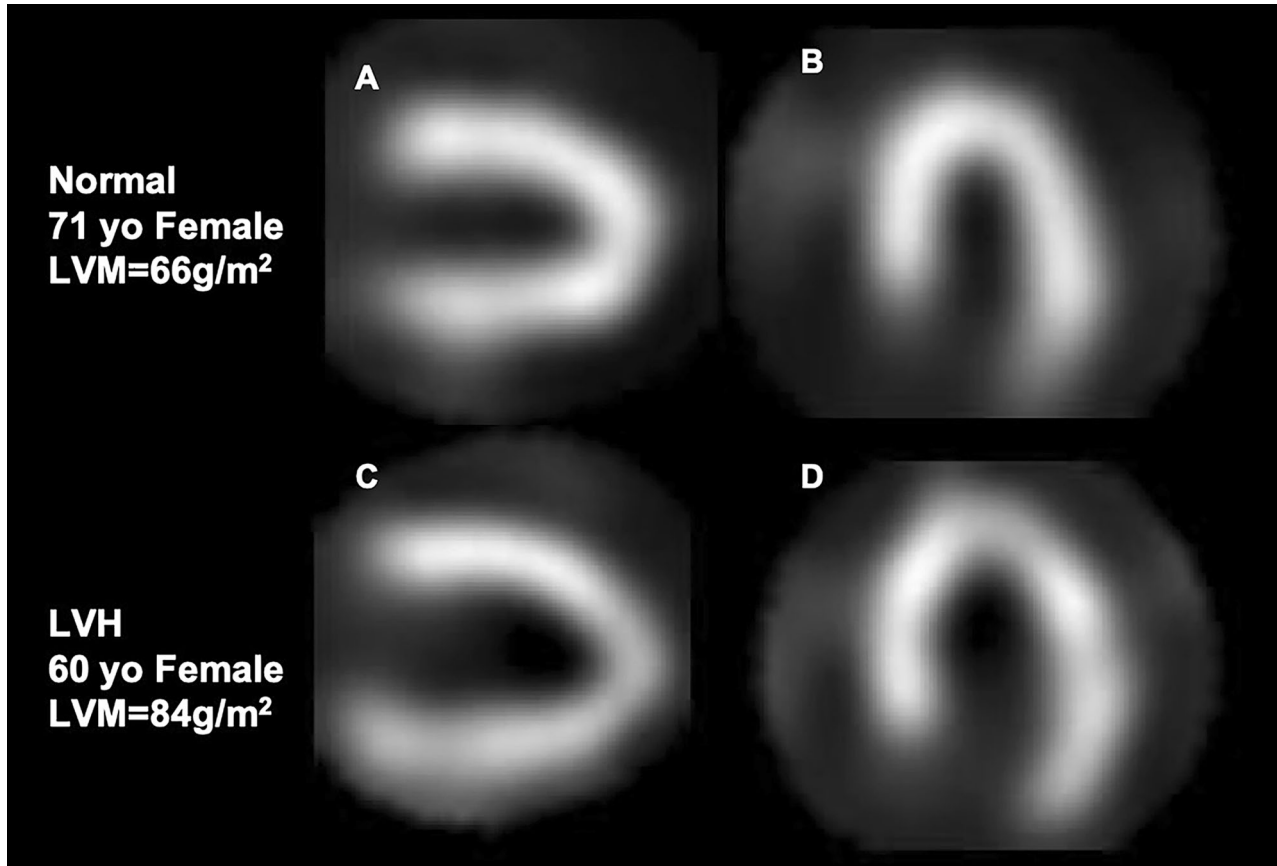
Left ventricular mass estimates. SPECT images were acquired (Discovery NM530c, GE Healthcare) 30 minutes after rest injection with Tc-99m tetrofosmin (~ 150 MBq, 4 mCi). Display zoom 1.3 for all images. A and B Normal patient. LVEF 74%, LVEDV 65 mL, LVESV 17 mL. C and D Patient with LVH. LVEF 50%, LVEDV 119 mL, LVESV 59 mL.
